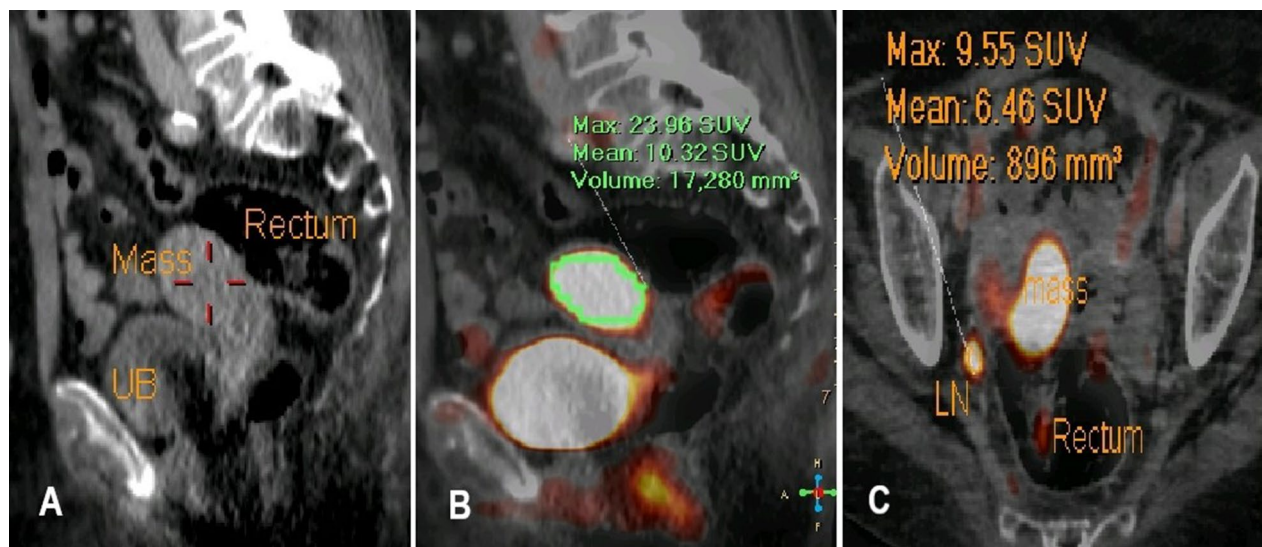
A large hypermetabolic endometrial soft tissue thickening [image A], mainly involving the left lateral aspect of the endometrium, measuring $\pm 36 \times 30 \times 41$ mm at its maximal AP, TR & CC dimensions having intense avidity for FDG uptake [23.9 SUV_{max}, SUV_{mean} 10.32 and MTV = 17,280 mm³], on corresponding PET image [image B]. Associated infiltration of more than 50% of the myometrial coat yet no associated extra uterine or parametrial extensions. Regional solitary right internal iliac LN is noted about 13 × 12 mm having intense metabolic activity [image C], 9.5 SUV_{max}, 6.46 SUV_{mean} and vol. = 896 mm³
